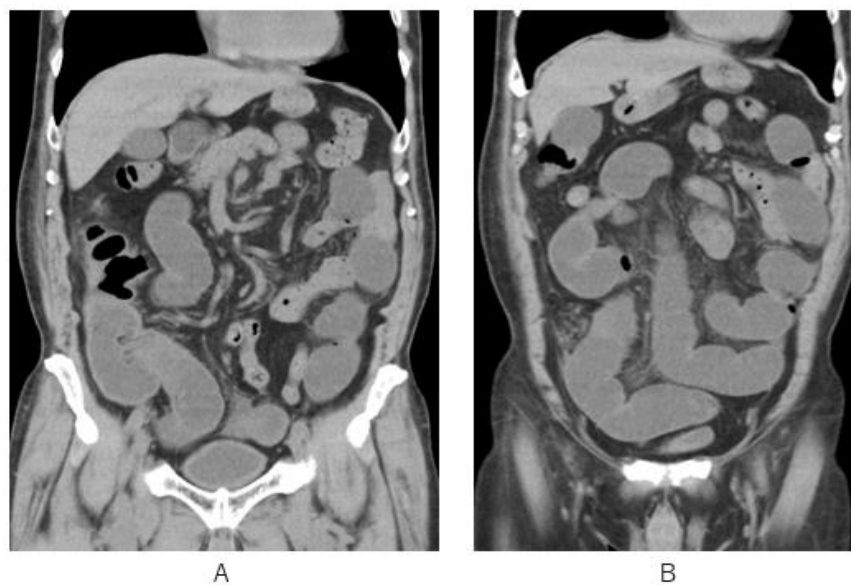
Coronal CT images depict dilated lower small bowel whose maximum diameter is 3cm or greater (A, B). Note the ileum end and cecum dilated with fluids and gas (A).
